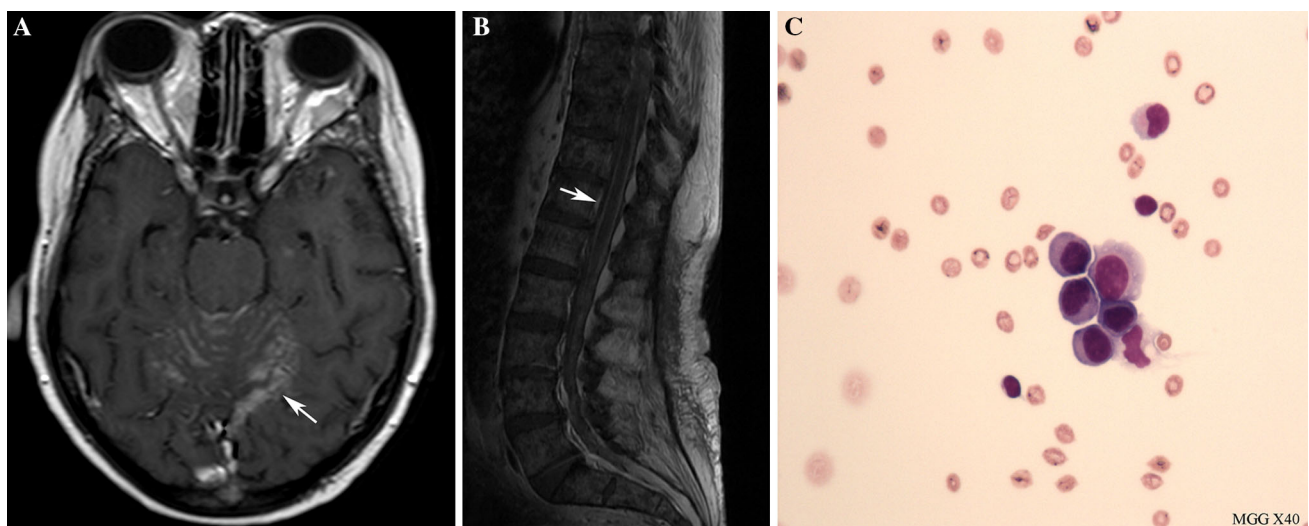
Cranial axial (a) and spinal sagittal (b) T1-weighted MRI depicting an enhancement of the leptomeninges (arrows). Photography (MGG X 40) revealing the presence of cancer cells into the CSF (c)
